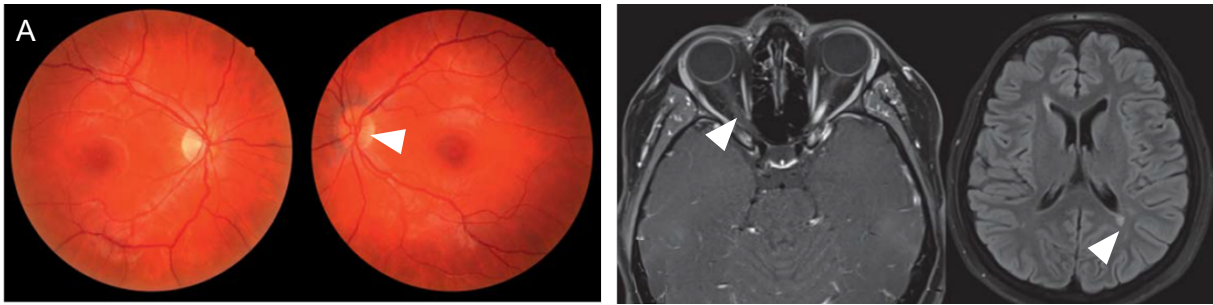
Optic neuritis via fundoscopy and MRI. 23-year-old female patient with optic neuritis and mild papilledema, marked with white arrow (A). Contrast-enhanced MRI of the same patient showing the inflammatory optic nerve and two periventricular areas of demyelination on T2-FLAIR MRI, marked with white arrows. Modified from Wilhelm and Schabet (Wilhelm & Schabet, 2015).
